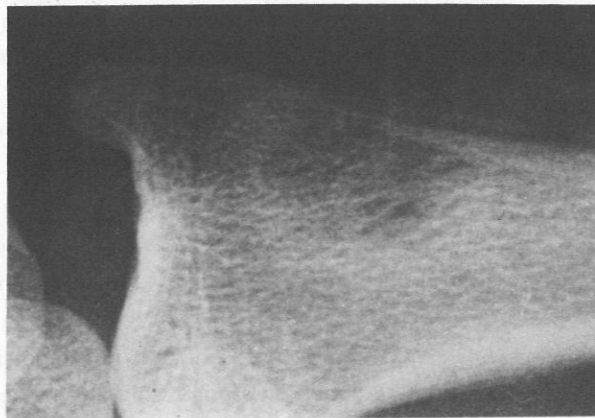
Note the friable trabecular arrangement radiating from the lytic lesion demonstrated by X-ray study.
